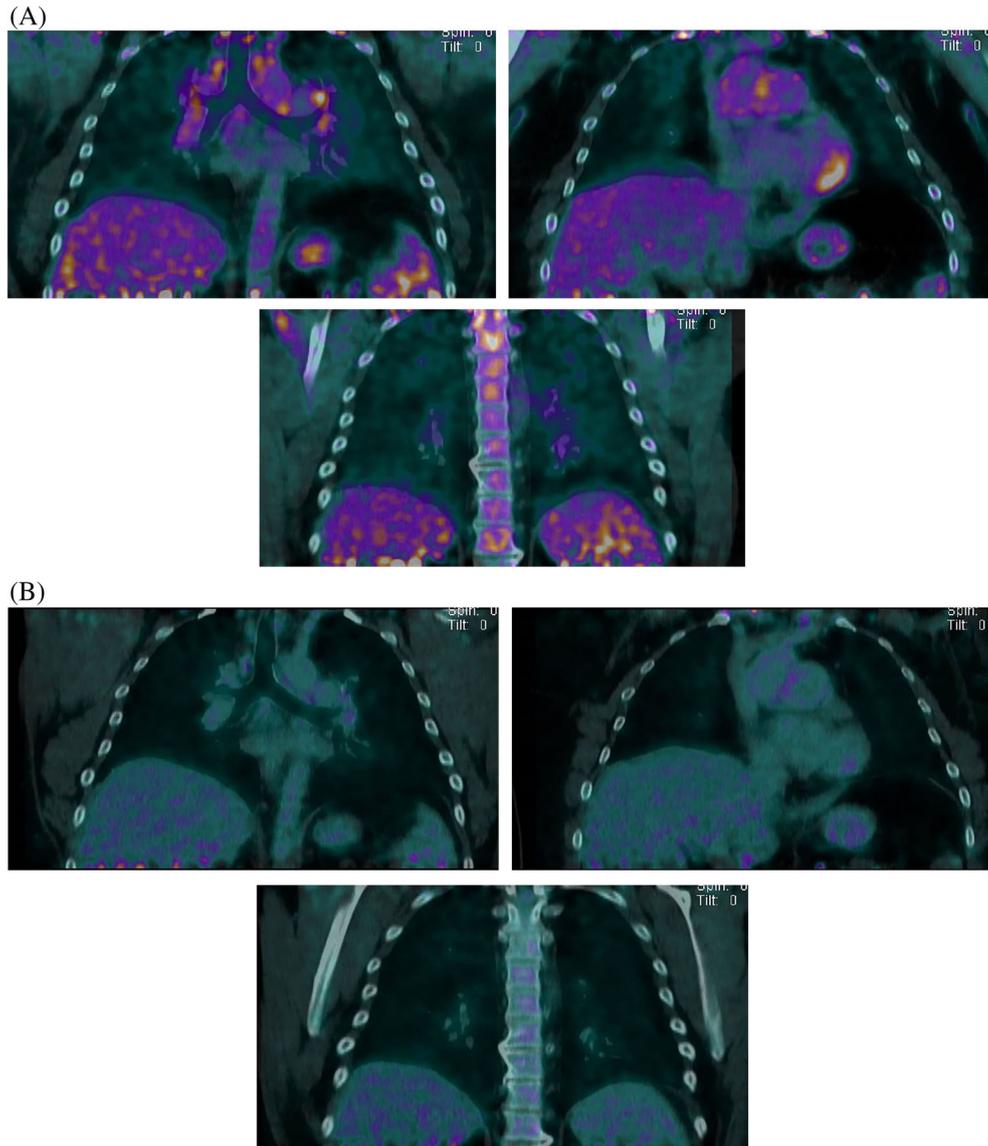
(A) ^{18}F -FDG PET scan prior to infliximab therapy demonstrating increased fluorodeoxyglucose (FDG) uptake in mediastinal lymph nodes, left ventricular wall, vertebral bone marrow and spleen, indicating extensive active sarcoidosis. (B) ^{18}F -FDG PET scan after eight doses of infliximab demonstrating complete resolution of previously observed sarcoidosis activity
